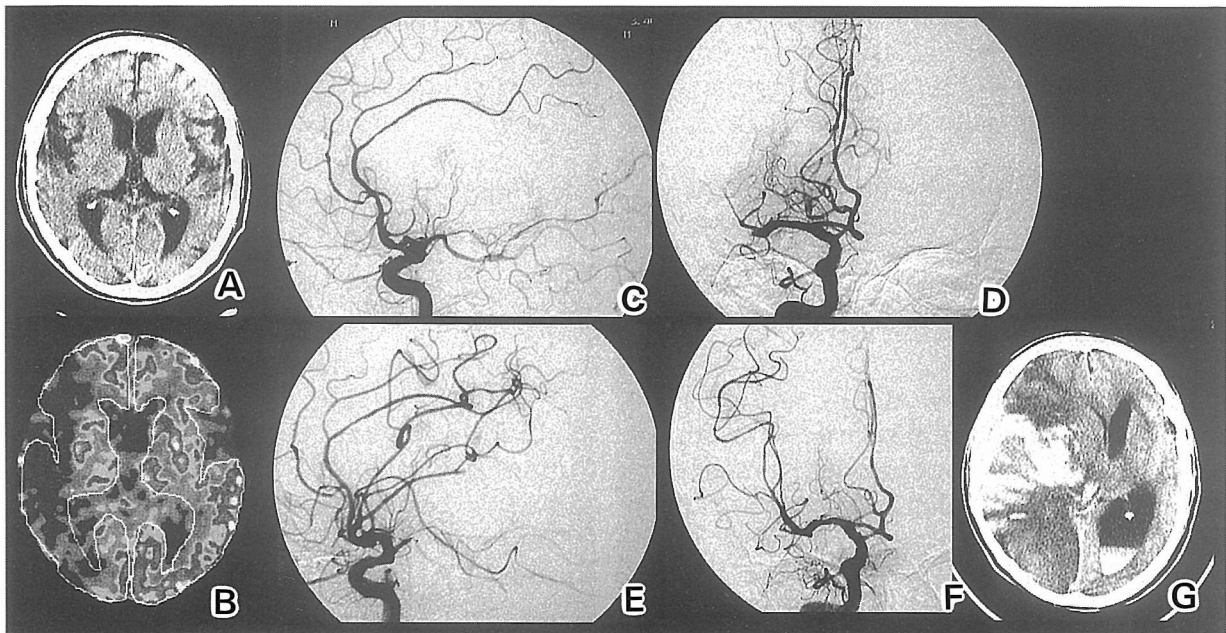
CT image, Xe-CT and angiograms of 74-year-old man with occluded right middle cerebral artery. A : CT image on admission showing no abnormal findings. B : Xe-CT. The white areas indicate high CBFs, and the dark ones low CBFs. The CBF is reduced in right MCA territory. C-D : The right carotid angiography on pre-thrombolysis showing right middle cerebral artery occlusion. C : lateral view, D : antero-posterior view. E-F : The right carotid angiography on post-thrombolysis showing recanalization of occluded middle cerebral artery. E : lateral view, F : antero-posterior view. G : CT image at 22 hours after recanalization showing large hemorrhagic infarction in right hemisphere with midline shift.
